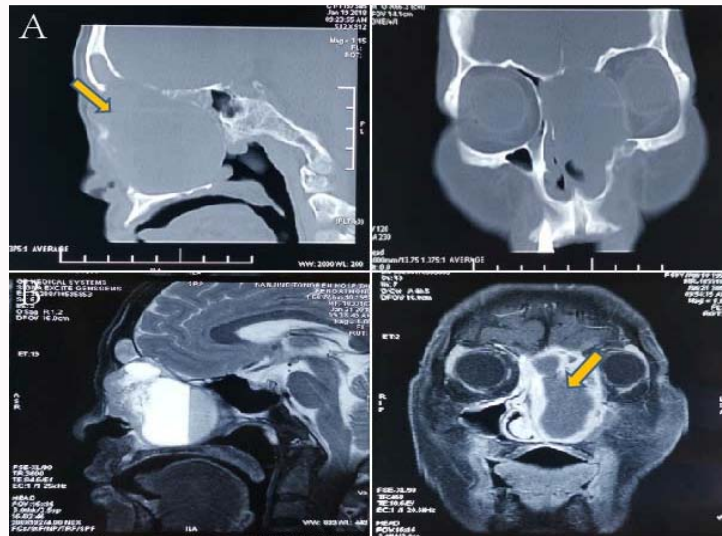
A: Large soft tissue shadow was seen in the left ethmoidal sinus (Yellow arrow), a cyst considered, compressing the surrounding bone and bone was defected on the ethmoidal top (CT). B: Large soft tissue shadow in the left ethmoidal sinus was visible (Yellow arrow), enhanced scan showed uneven enhancement (MRI).
